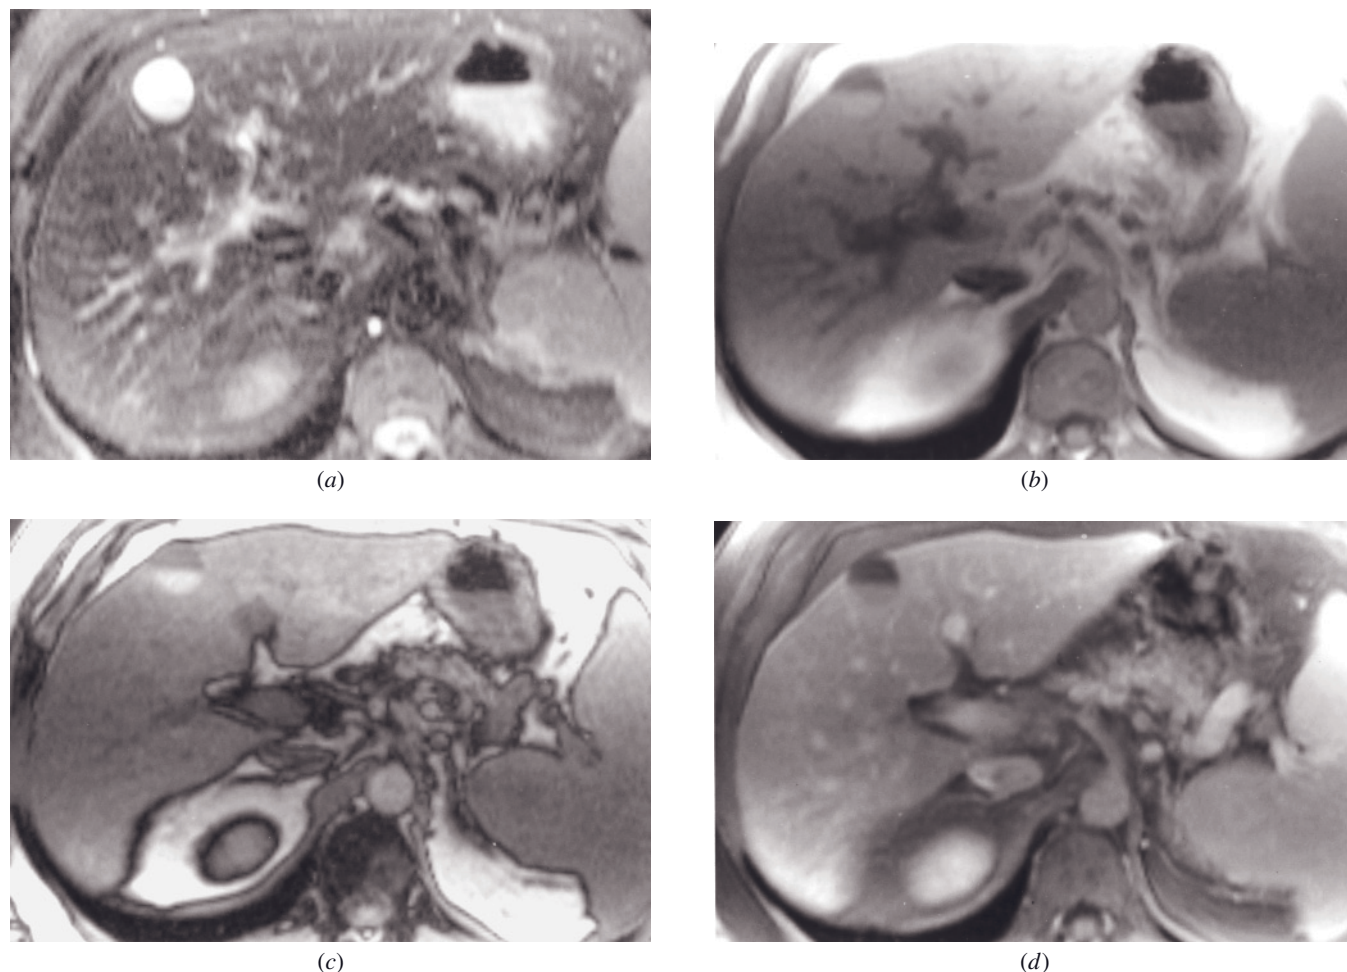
Foregut cyst with layering. Echo train-STIR (a), SGE (b), out-of-phase SGE (c), and 90-s fat-suppressed postgadolinium SGE (d) images. A cystic lesion is identified in segment 4 and distorts the anterior liver contour. The lesion is homogeneously high signal on T2-weighted image (a) and shows layering with high signal intensity on T1-weighted image (b), which does not lose signal on out-of-phase image (c), consistent with proteinaceous material (mucin) observed in these cysts.
